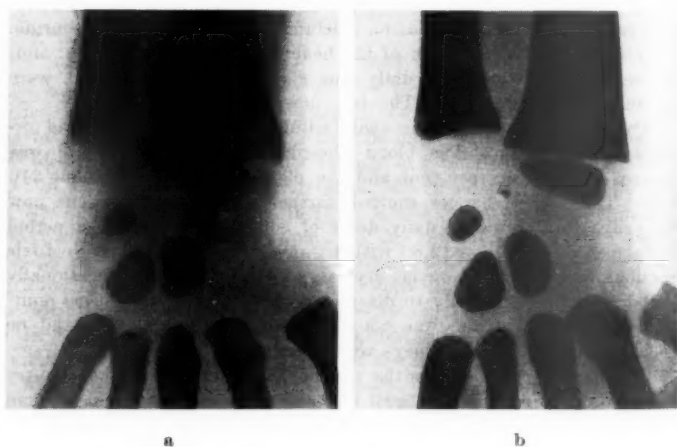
X-ray of the left wrist (a) 13.11.1946 and (b) 12.6.1947.
